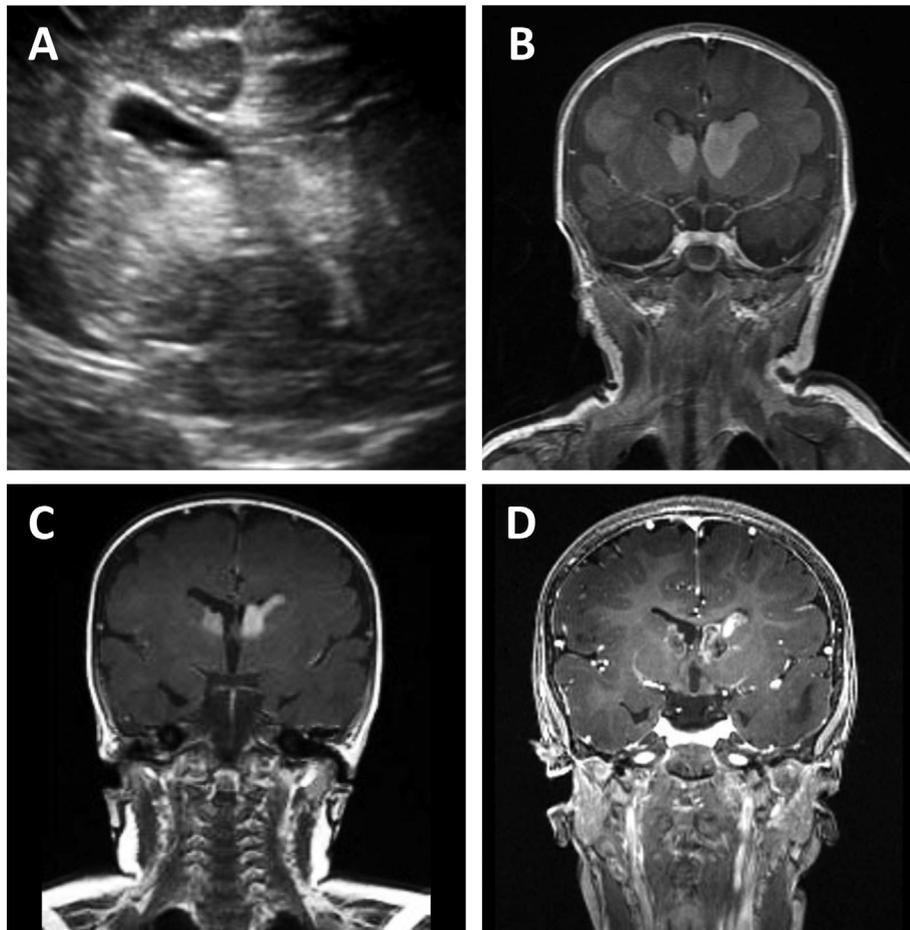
EVEROLIMUS TREATMENT OF TSC INFANT WITH CONGENITAL SEGA. (A) Head ultrasound performed on first day of life, demonstrating bilateral large sega. (B) Coronal T1 MRI with gadolinium demonstrating same SEGA on fifth day of life. (C) Coronal T1 MRI with gadolinium obtained at 5 months of age, demonstrating marked reduction of SEGA following everolimus treatment that was initiated on day of life 26. (D) Coronal T1 MRI with gadolinium obtained after continued treatment with everolimus, now 44 months of age. SEGA in interim have developed significant calcification and tumor volume continues to be reduced compared to baseline.
